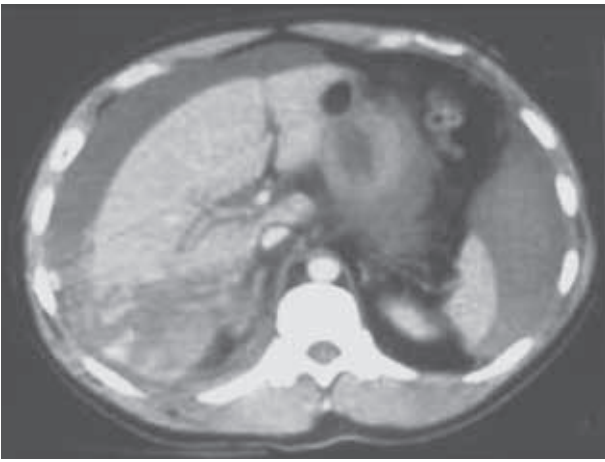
Liver damage (CT)
